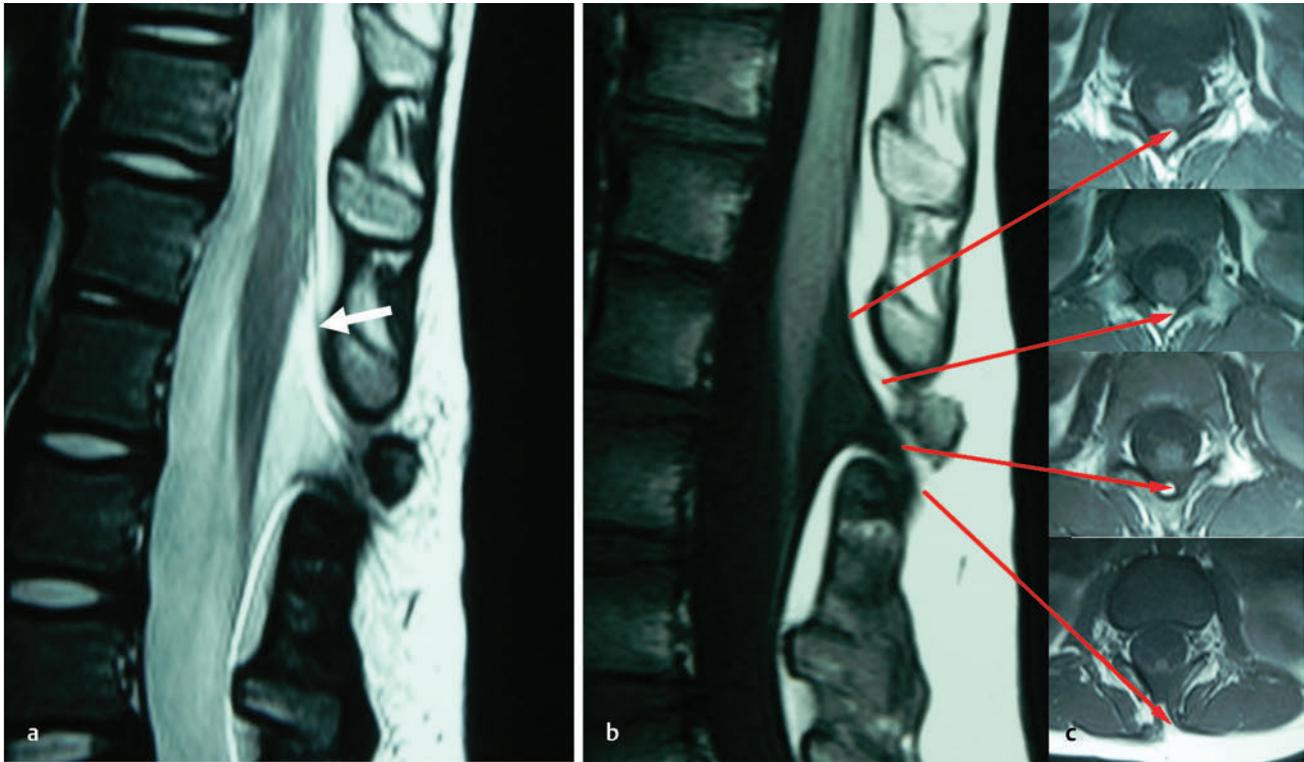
(a) T2-weighted sagittal magnetic resonance (MR) image showing features of meningocele manqué, including a meningocele, tapered conus, dorsal tethering bands (*arrow*), and a rudimentary disk at level of the dysplastic lamina. (b) T1-weighted MR image of the same section as in (c) axial images. Adjacent axial images show a dorsal lipomatous stalk descending from the conus to exit the spinal canal through a bifid spinous process and passing into the subcutaneous fat (lowest image).
